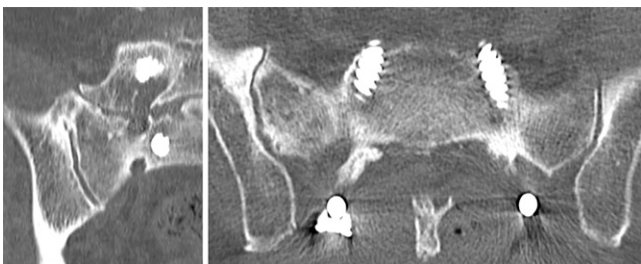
CT scans after reoperation. Left: Coronal CT image showing reinsertion of the right S1 pedicle screw toward the inside of the S1 anterior foramen. Right: Axial CT image showing reinsertion of the bilateral S1 pedicle screws toward the apex of the sacral promontory over bicortical fixation.
